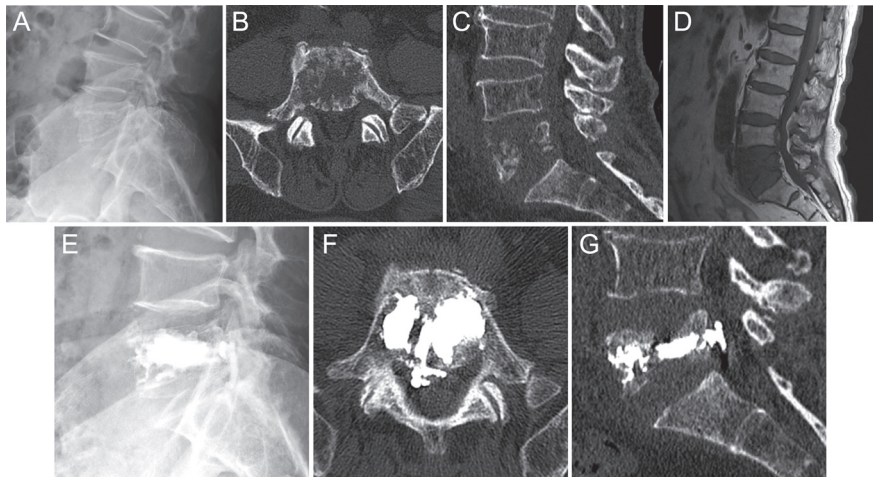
A-G. (A) Preoperative lateral radiograph showing a metastatic spinal compression fractures of L5. (B-C) Preoperative axial and sagittal CT scan showing a bone destruction in the L5 vertebral body. (D) Preoperative lateral MRI showing a metastatic spinal compression fractures of L5. (E) Postoperative lateral radiograph showing cement leakage after undergoing PKP surgery of L5 metastatic spinal compression fractures. (F-G) Postoperative axial and sagittal CT scan showing cement leakage after undergoing PKP surgery of L5 metastatic spinal compression fractures. CT, computed tomography; MRI, magnetic resonance imaging; PKP, percutaneous kyphoplasty.
